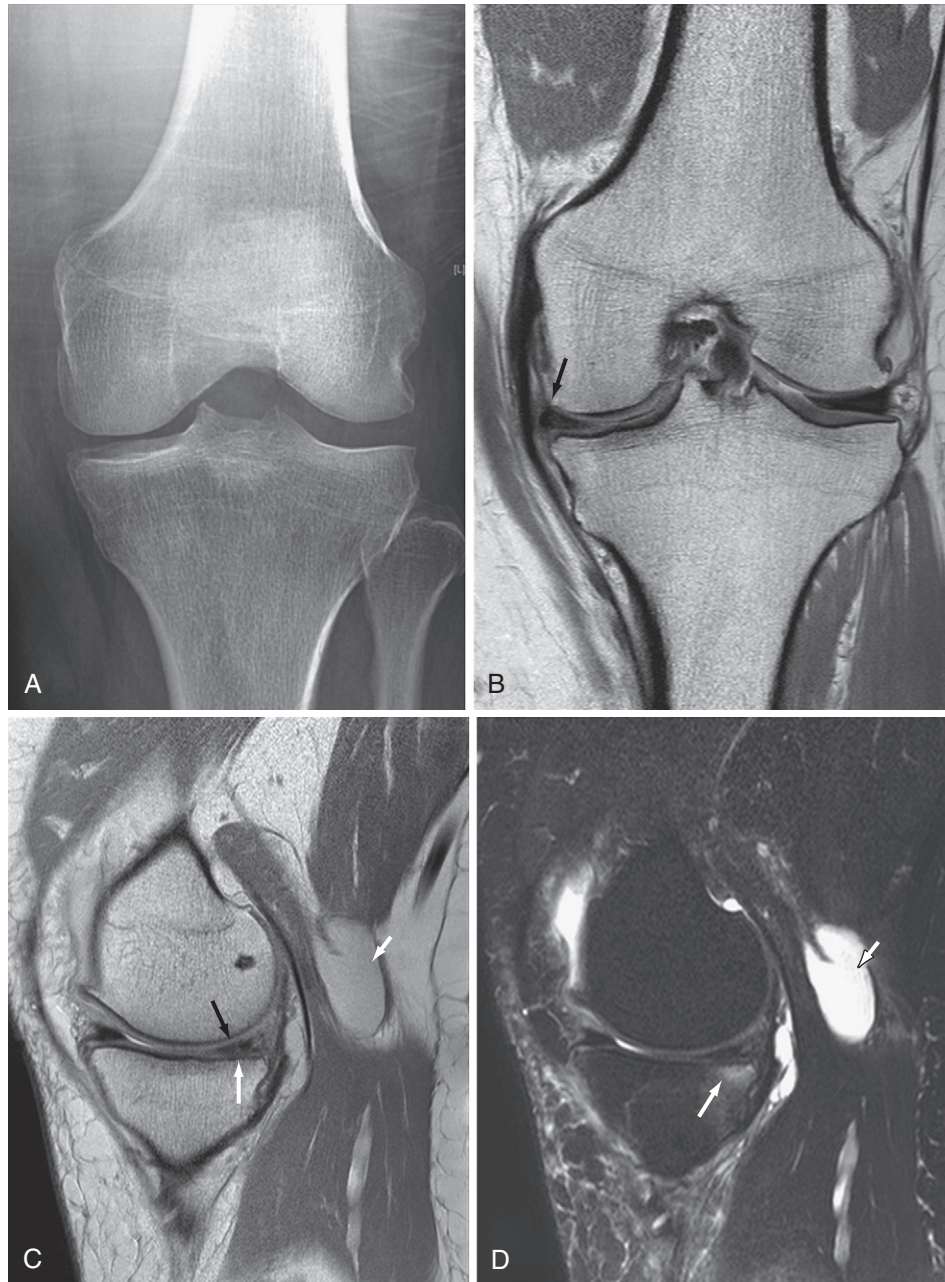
Early osteoarthritis (OA) of the knee (x-ray and magnetic resonance imaging [MRI]). X-ray (A) and MRI (B through D) of the knee with early OA. A, Anteroposterior x-ray view shows an almost normal knee. The only possible abnormality is a tiny osteophyte at the medial tibial plateau. B, Coronal proton density-weighted MRI shows a minimal medial meniscus subluxation (*arrow*). C, Sagittal proton density-weighted MRI shows partial maceration of the posterior horn of the medial meniscus (*black arrow*), thinning of the cartilage at the posterior medial tibial plateau (*long white arrow*), and a moderate-sized Baker's cyst (*short white arrow*). D, Sagittal fat-suppressed T2-weighted MRI confirms the Baker's cyst (*short arrow*) and also shows subchondral bone marrow edema (*long arrow*) subjacent to the loss of cartilage at the posterior subregion of the medial tibial plateau. (Courtesy Professor Ali Guermazi, Boston, Mass.)
